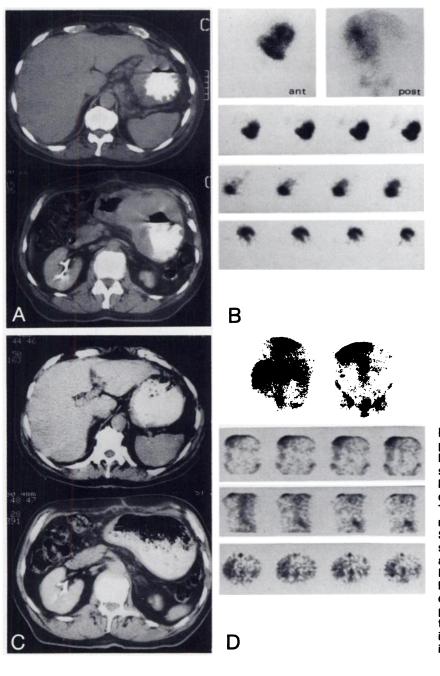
Case 2: Diffuse, large cell, predominantly noncleaved, non-Hodgkin's lymphoma of the stomach. (A) CT scans at the level of the upper and lower part of the stomach showing a diffuse thickening of the gastric wall. There is also gastrohepatic lymphadenopathy. (B) Gallium-67 planar and SPECT scintigraphy in the coronal, sagittal, and transaxial planes showing abnormal uptake in the gastric wall. (C) Post-treatment CT scans at the same levels as in (A), showing residual thickening of the gastric wall. (D) Gallium-67 planar and SPECT scintigraphy after therapy showing no abnormal uptake in the stomach. Superficial focal uptake is seen in the postoperative scar tissue.
